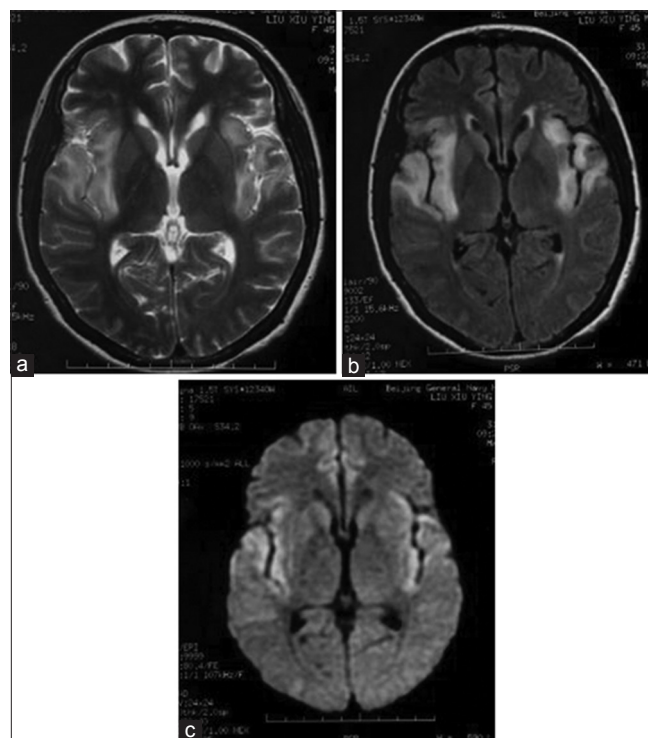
Magnetic resonance imaging representations of a herpes simplex virus encephalitis patient with intelligent obstacle and epilepsy seizure: high signal on T2-weighted image, fluid-attenuated inversion recovery (FLAIR) image and diffusion-weighted imaging (DWI) image on bilateral temporal lobe and insular lobe. (a) T2-weighted image; (b) FLAIR image; (c) DWI image
